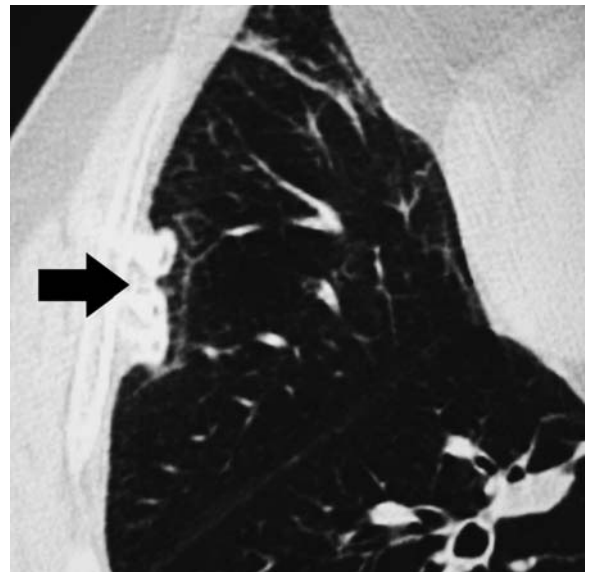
Thin-section computed tomography of a calcified pleural plaque (arrow) showing adjacent interstitial parenchymal lines
